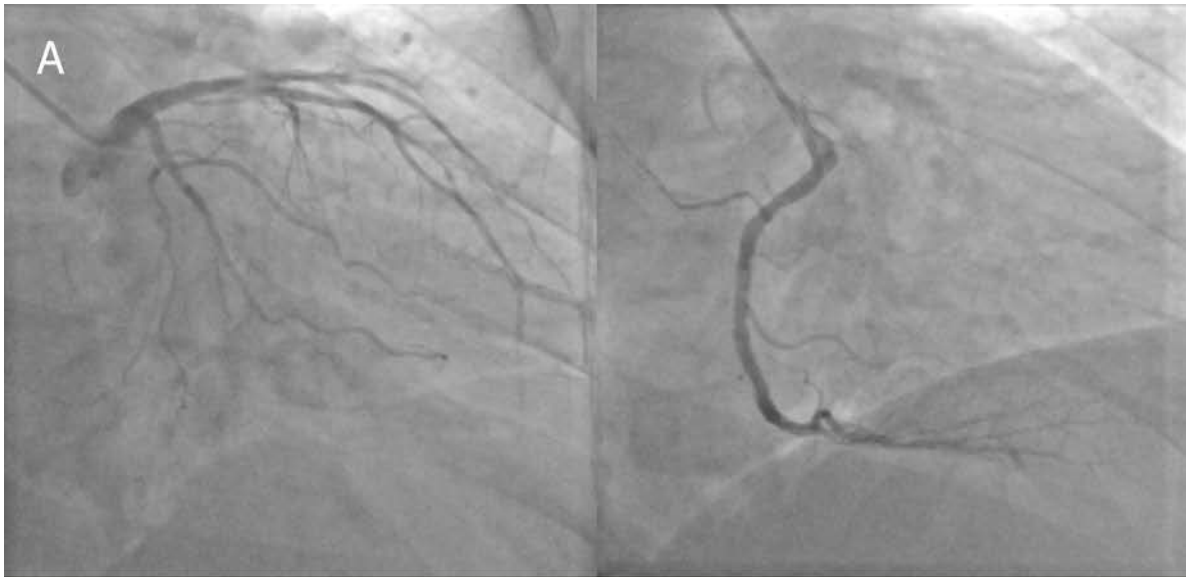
Coronary angiography showing non-obstructed epicardial coronary arteries (A). The timeline of subsequent diagnostic and therapeutic stages (B). Magnetic resonance imaging brain FLAIR sequence showing an extensive area of malacic lesions in the right temporal lobe (blue arrow). Furthermore, there were single small areas of raised signal in the right cerebral hemisphere, consistent with nonspecific demyelinating lesions, primarily ischemic (yellow arrows) (C)
